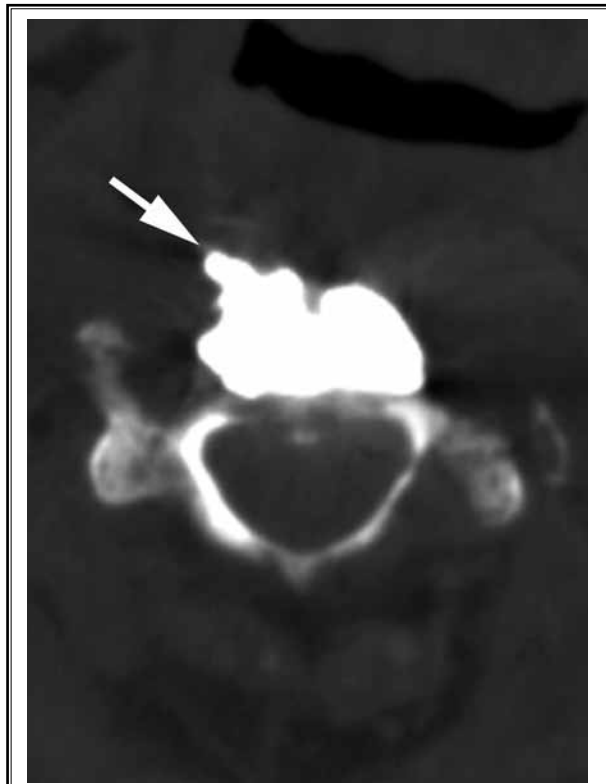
This post-operative CT image shows cement leakages in the prevertebral space (arrow).
